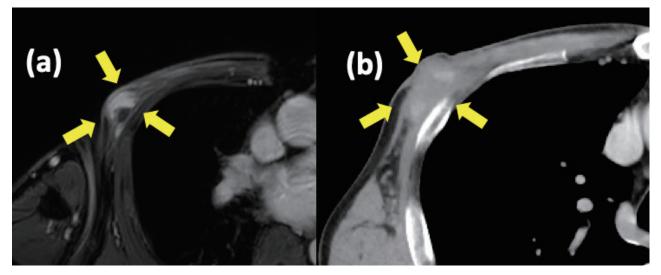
Imaging findings at the time of recurrence. Results of both magnetic resonance imaging (a) and computed tomography (b) suggested tumor recurrence and muscle invasion into the chest wall (yellow arrow).
